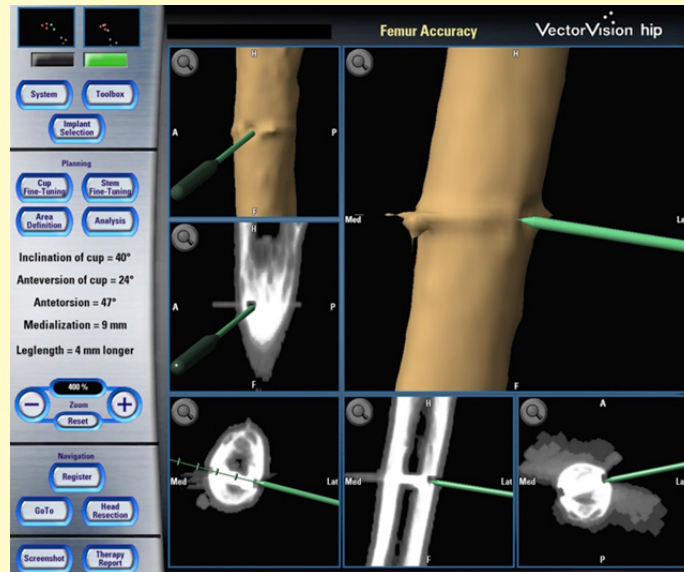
Hidden broken screw was pointed out by CT-based navigation.
